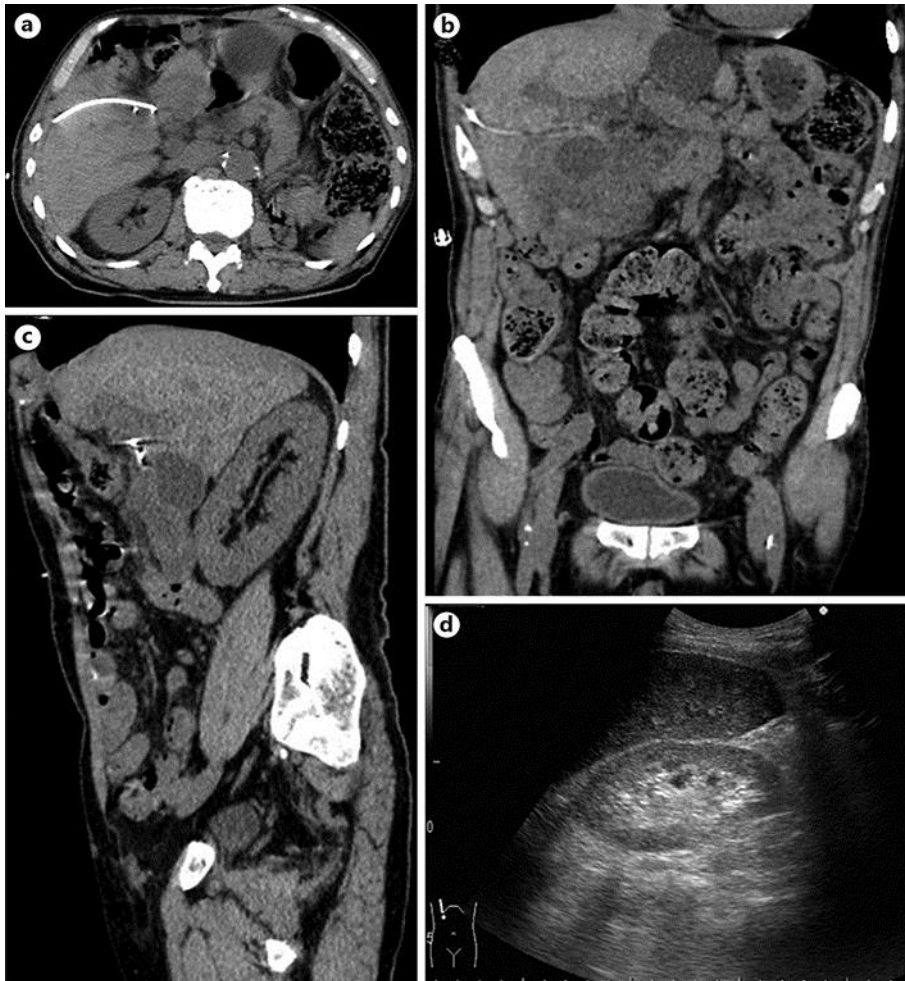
CT performed 18 days after catheter insertion showed marked regression of the hepatic cyst (a, b) and relief of the ureteral obstruction (c). d Abdominal US showed relief of right hydronephrosis.
